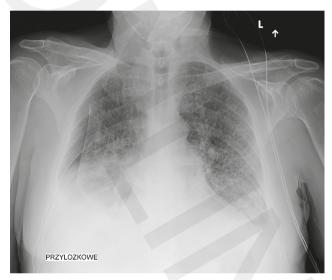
Chest radiograph after thoracocentesis (right-sided pneumothorax)
